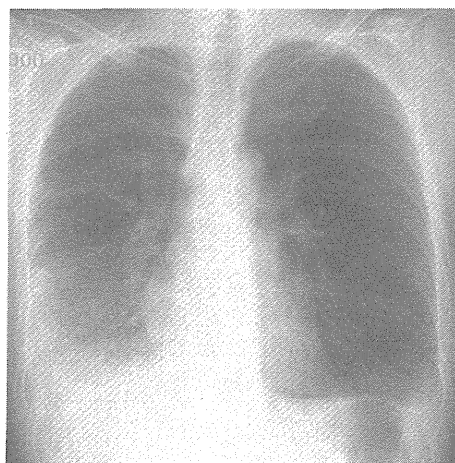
Chest X-ray on admission showed bilateral GGO and consolidation.
